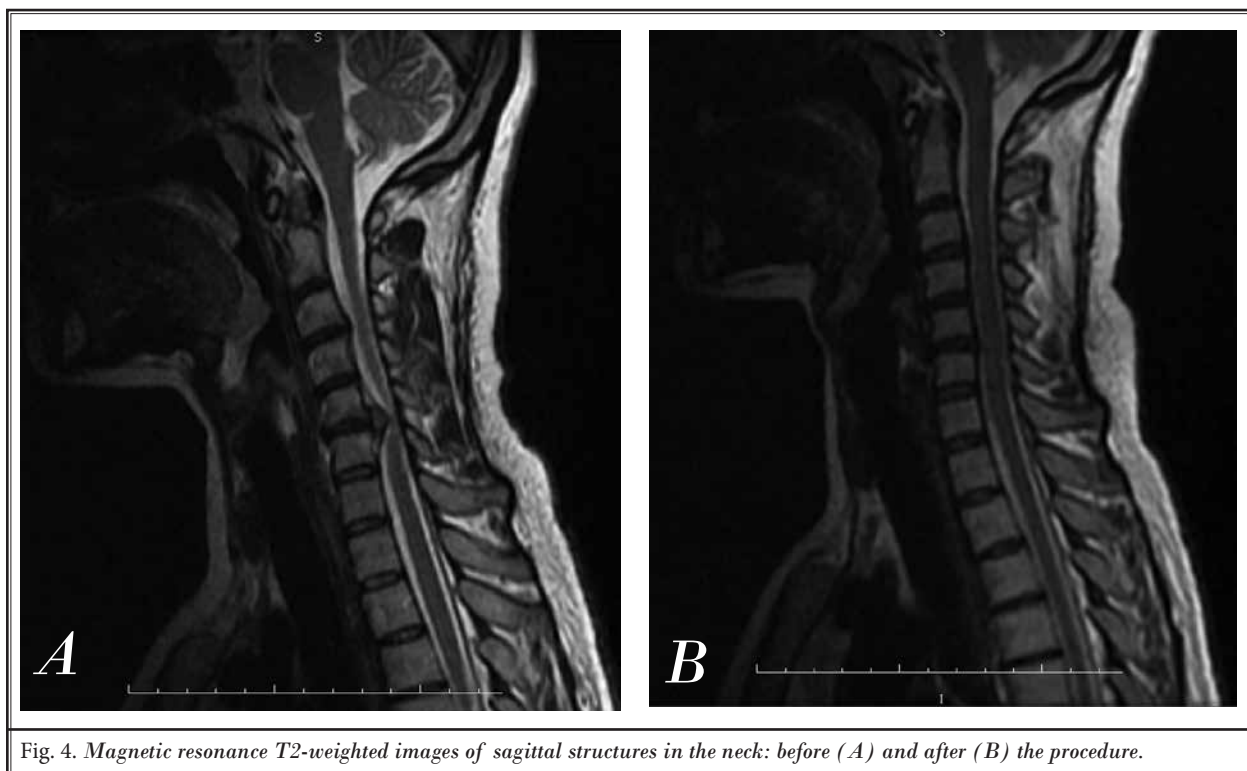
Magnetic resonance T2-weighted images of sagittal structures in the neck: before (A) and after (B) the procedure.
